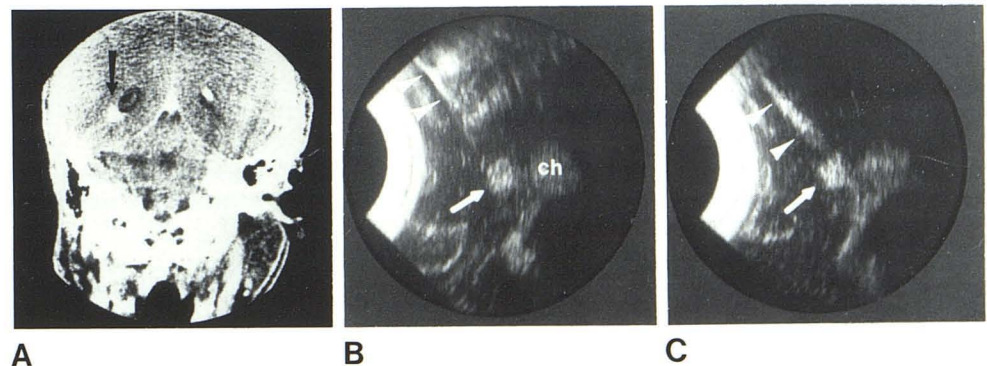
Case 2: thrombosed arteriovenous malformation. A, Preoperative contrast-enhanced coronal CT. Target tissue for biopsy (arrow) at inferolateral border of left ventricular atrium. B, Intraoperative coronal sonogram during passage of blunt cannula. Target tissue (arrow) is distinct from choroid plexus (ch) of atrium and temporal horn. Metal cannula (arrowheads) produces artifactual reverberations on far side from transducer but remains clearly visible during passage. C, Coronal sonogram after forceps biopsy demonstrates tract (arrowheads) produced by cannula and shows no apparent growth in lesion size (arrow) to indicate hemorrhage.
